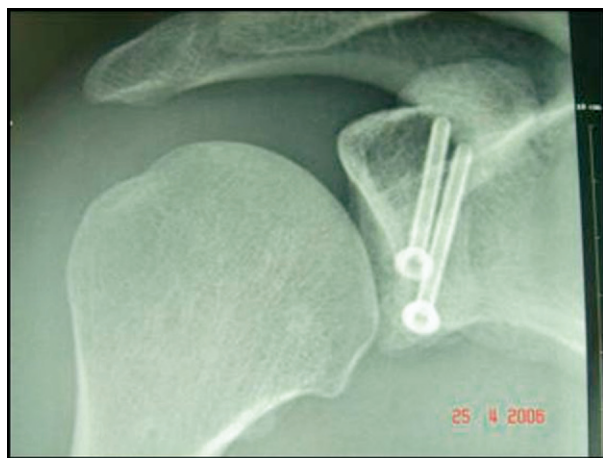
Final radiograph showing screw placement after arthroscopic Latarjet procedure.
